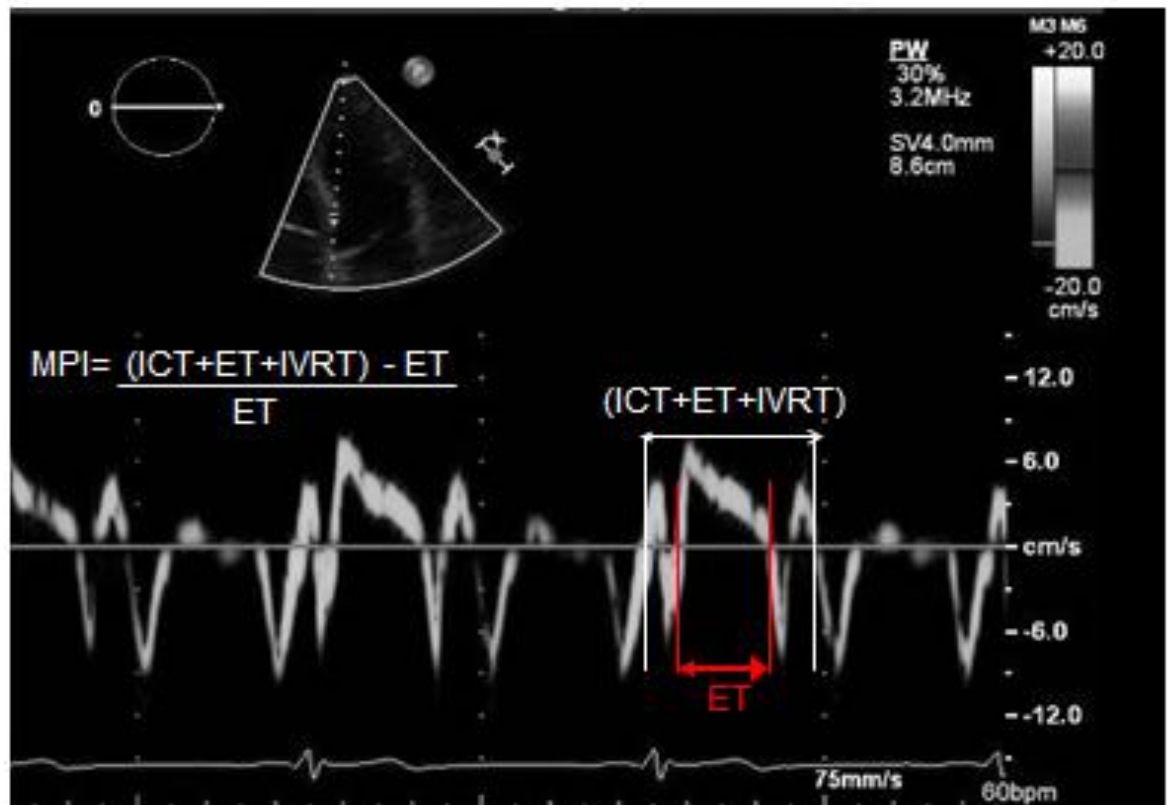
Recording of MPI using pulsed wave tissue Doppler imaging at septal site of the left ventricle from an apical 4-chamber view. MPI=myocardial performance index, ICT=isovolumic contraction time, ET=ejection time, IVRT=isovolumic relaxation time
